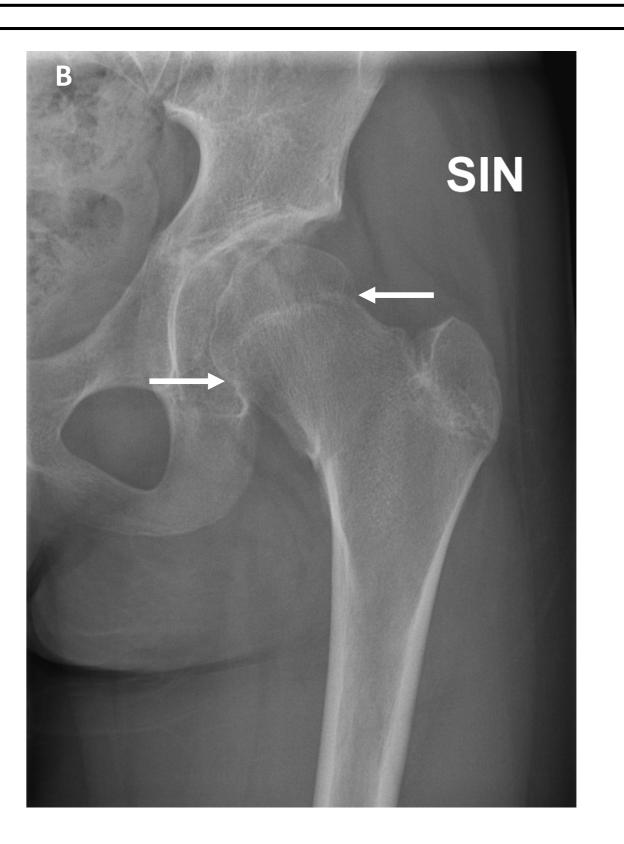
Radiographs of knee (A), hip (B), and shoulder (C) after 18 months of palovarotene treatment. She was 11 4/12 years of age and prepubertal at the time. Arrows point at fused growth plates.
